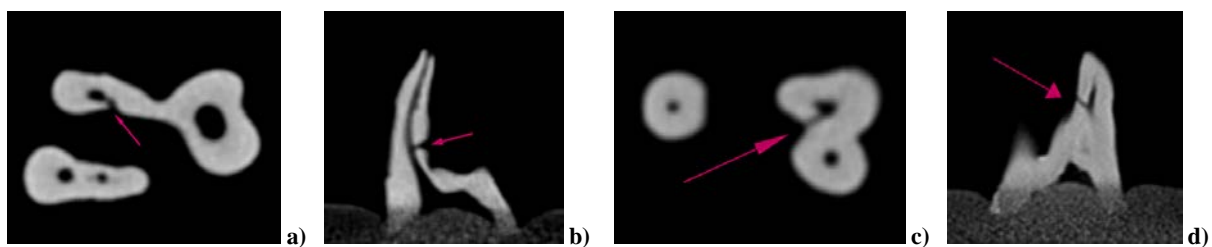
Cone-beam computed tomography (CBCT) sections presenting pulpo-periodontal communications (PPCs) specific for maxillary first molars with fused roots: a) axial section showing palatal (P) to distobuccal (DB) type of root fusion with PPCs in DB root canal with mesio-palatal (MP) orientation (arrow); b) sagittal section of the same PPCs at the coronal to mid-root location (arrow); c) axial scan of mesiobuccal (MB) to DB type of root fusion with PPCs in MB root canal (arrow); d) sagittal scan of the same MB root showing mid-root located PPCs (arrow).
